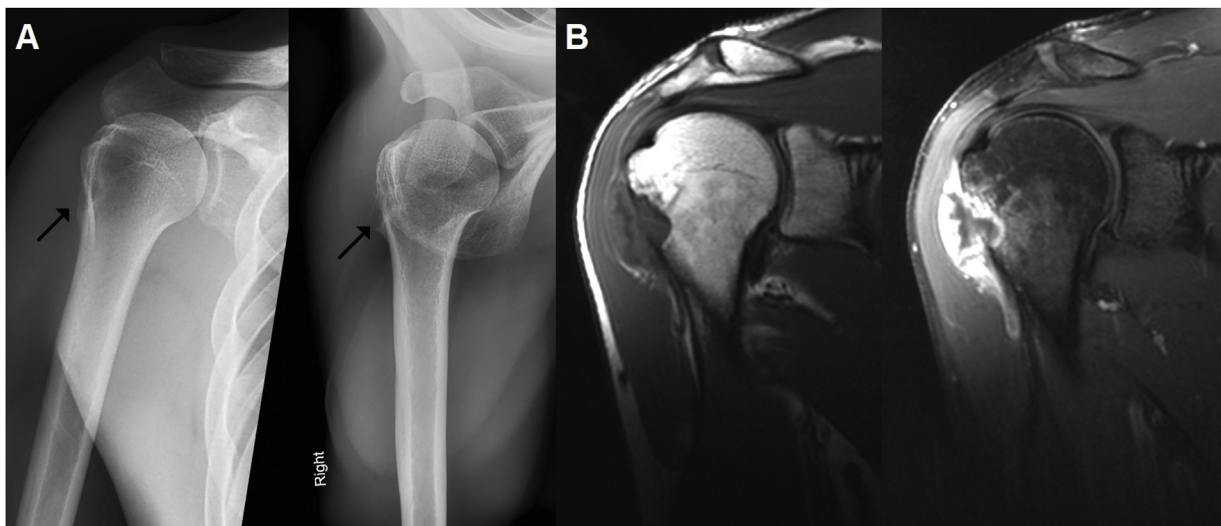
(A) Initial AP and axillary radiographs of the right shoulder. The arrows demonstrate a lytic area involving the lateral aspect of the proximal humerus with a periosteal reaction. (B) Initial coronal T1- and T1-contrast enhanced MRI's of the right shoulder demonstrating a tumor involving the proximal humerus with cortical breakthrough and an associated soft tissue mass.
